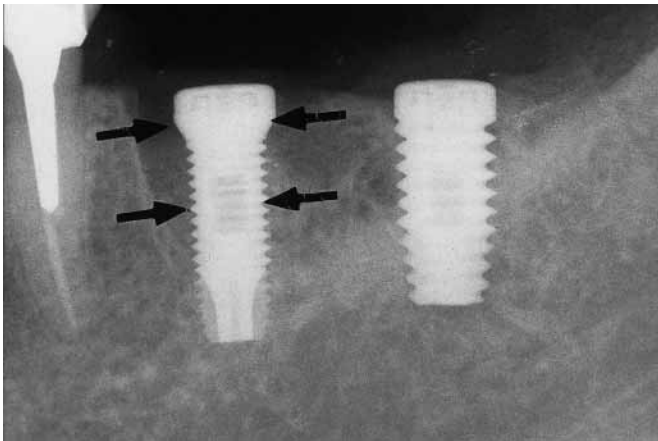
Radiograph control after immediate placement of an Osseotite XP™ implant following extraction. Note the expanded platform implant design. The initial stability is increased because the flared coronal aspect engages the crestal bone.
